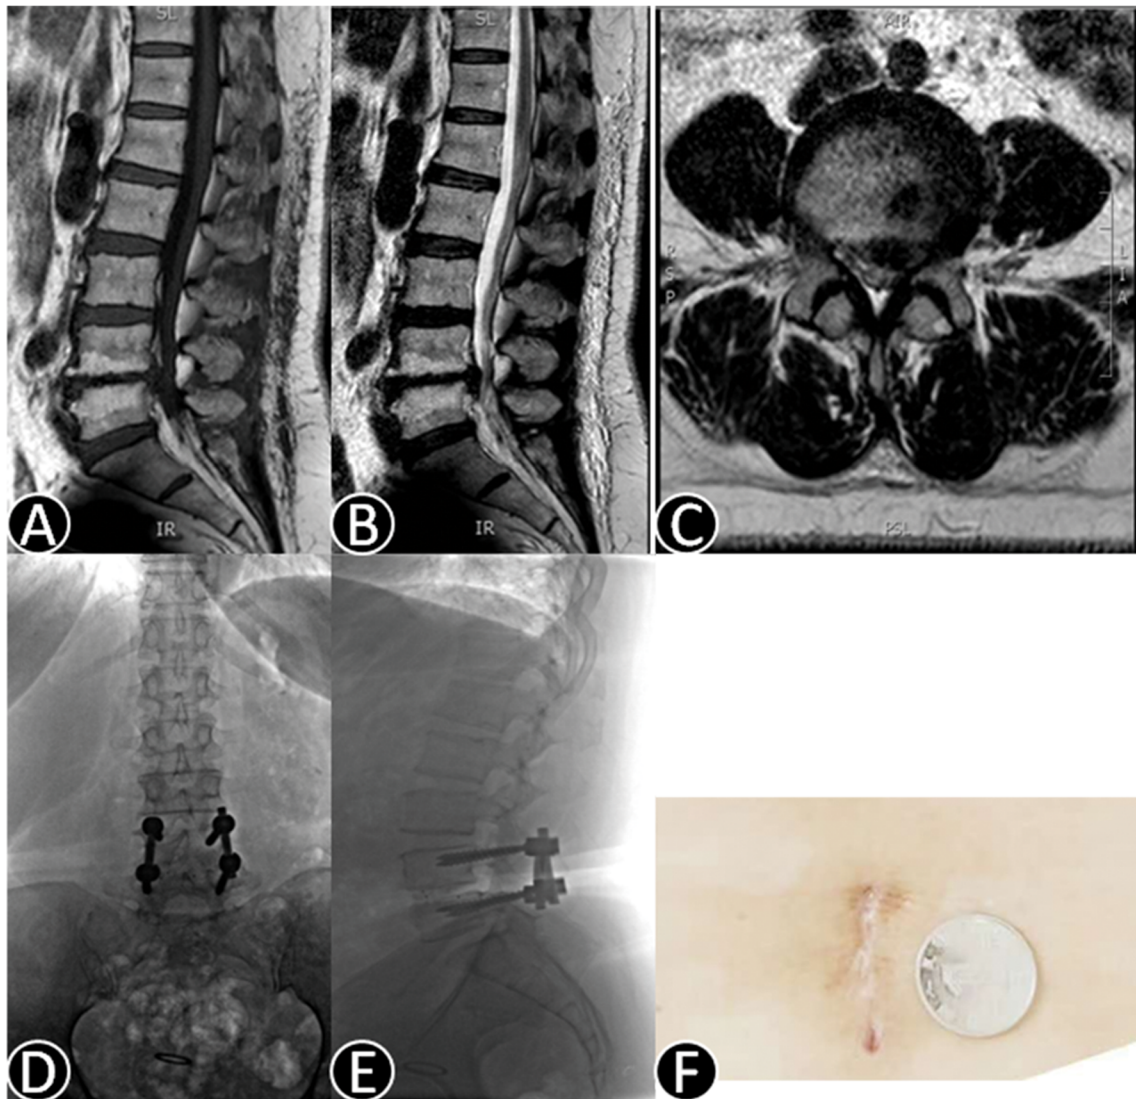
A 52-year-old male patient with low back pain and left leg pain. (A) Sagittal T1-weighted, (B) sagittal, and (C) axial T2-weighted MRI of a patient with severe L4–5 lumbar stenosis. (D, E) X-ray photographs after surgery. (F) Mini-open incision to accomplish minimally invasive transforaminal lumbar interbody fusion (Mis-TLIF).
